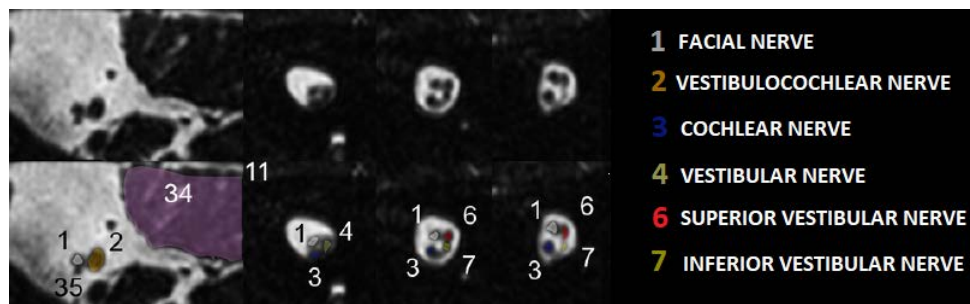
Sagittal series of a high-resolution T2-weighted MR image showing the sections of the internal auditory canal from medial to lateral part. The colored numbers distinguish the main nerves that result to be very close one to each other. Adapted from [2].
